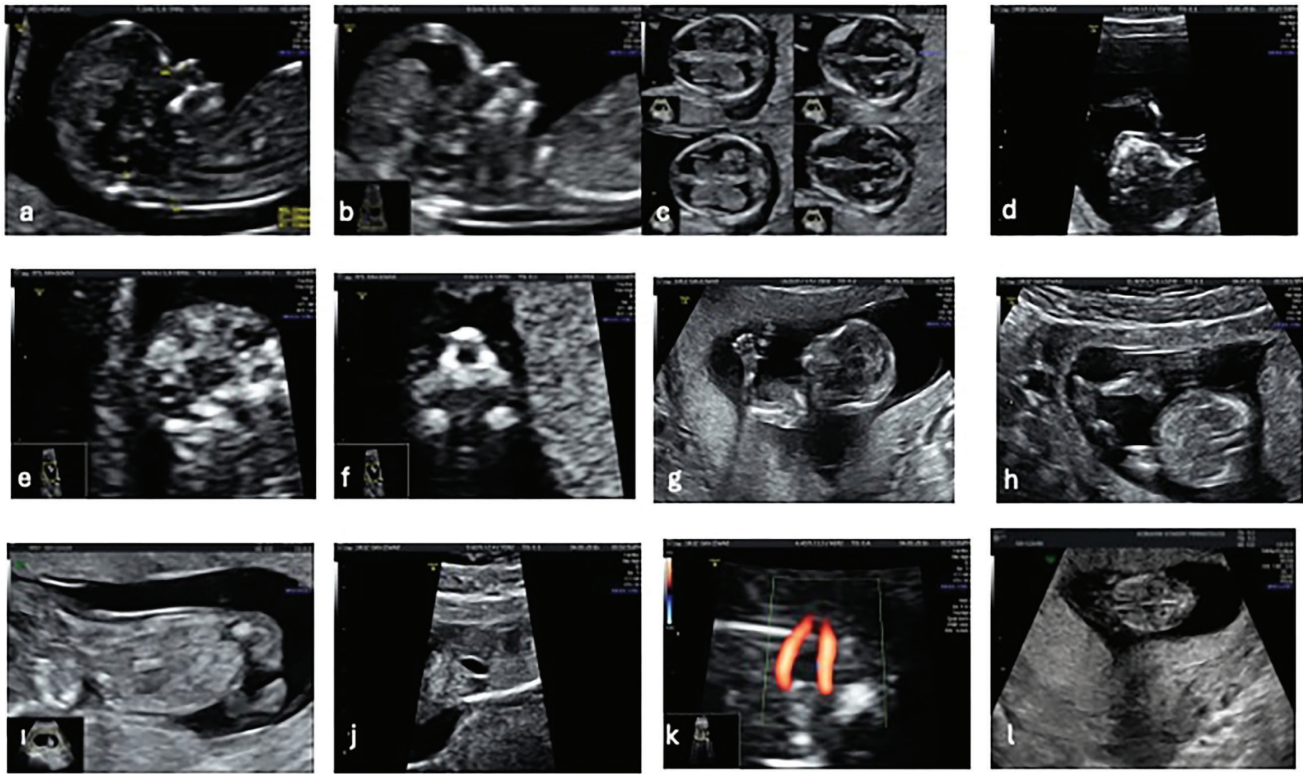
Standard sonographic planes for anatomical survey in the first-trimester exam. Fetal profile view to measure NT (a), fetal profile in the mid-sagittal view (b), axial planes of fetal cranium (c) , axial view of hard palate (d), bilateral orbita and lenses (e), retronasal triangle (f), upper extremity, hand, and fingers (g), lower extremity and foot (h), skin overlying fetal spine (i), fetal stomach (j), fetal bladder and bilateral umbilical arteries (k), bilateral kidneys (l)
